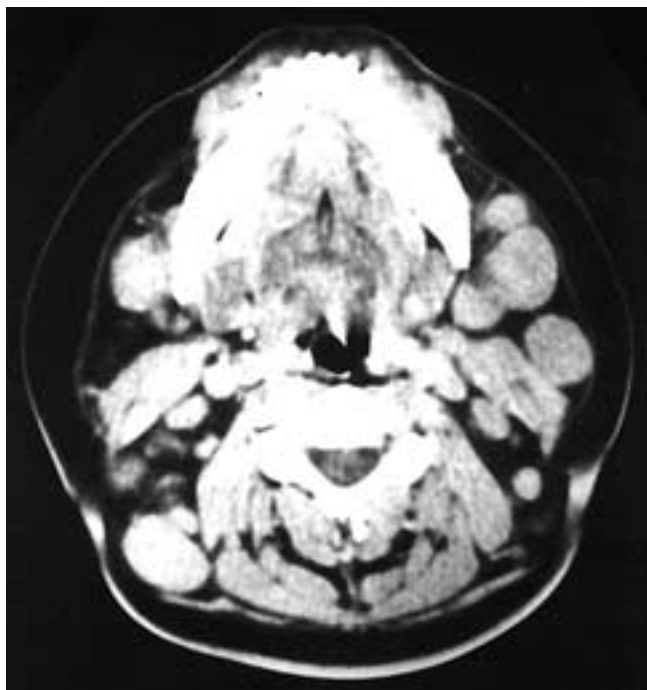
Axial contrast-enhanced CT scan shows multiple enlarged, homogeneous nodes with no infiltration of the adjacent fat planes. This patient had sarcoidosis.
